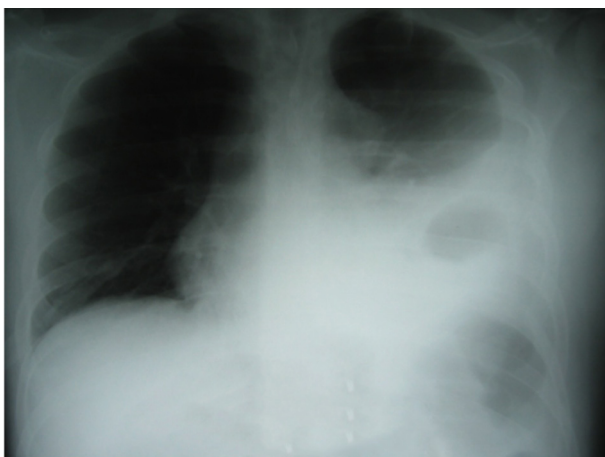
Pre-Operative Chest X-Ray (CXR) Demonstrating a Left Sided Pleural Effusion With a Loop of Bowel Within the Left Hemithorax
